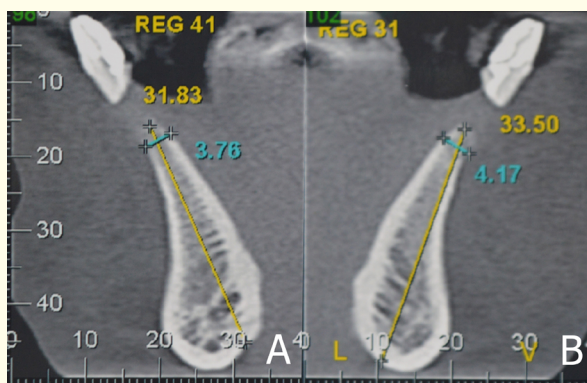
Bone maintenance presented by cone beam computed tomography after 6 months.
